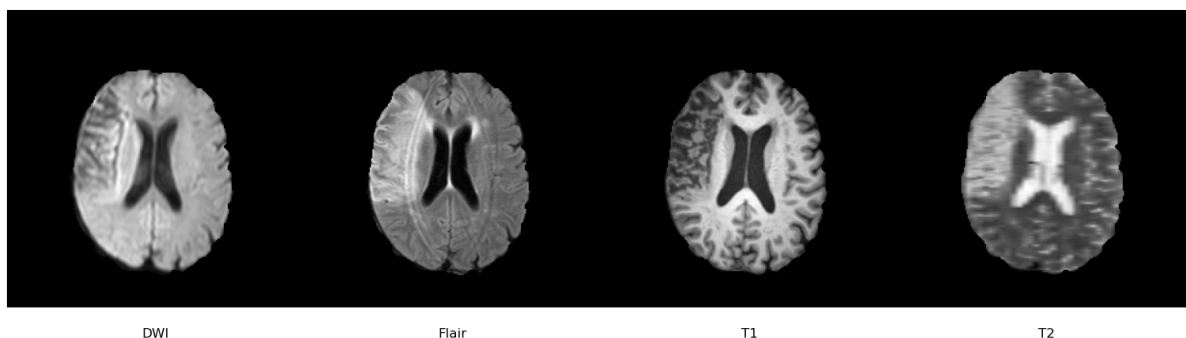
Different MRI modalities.
